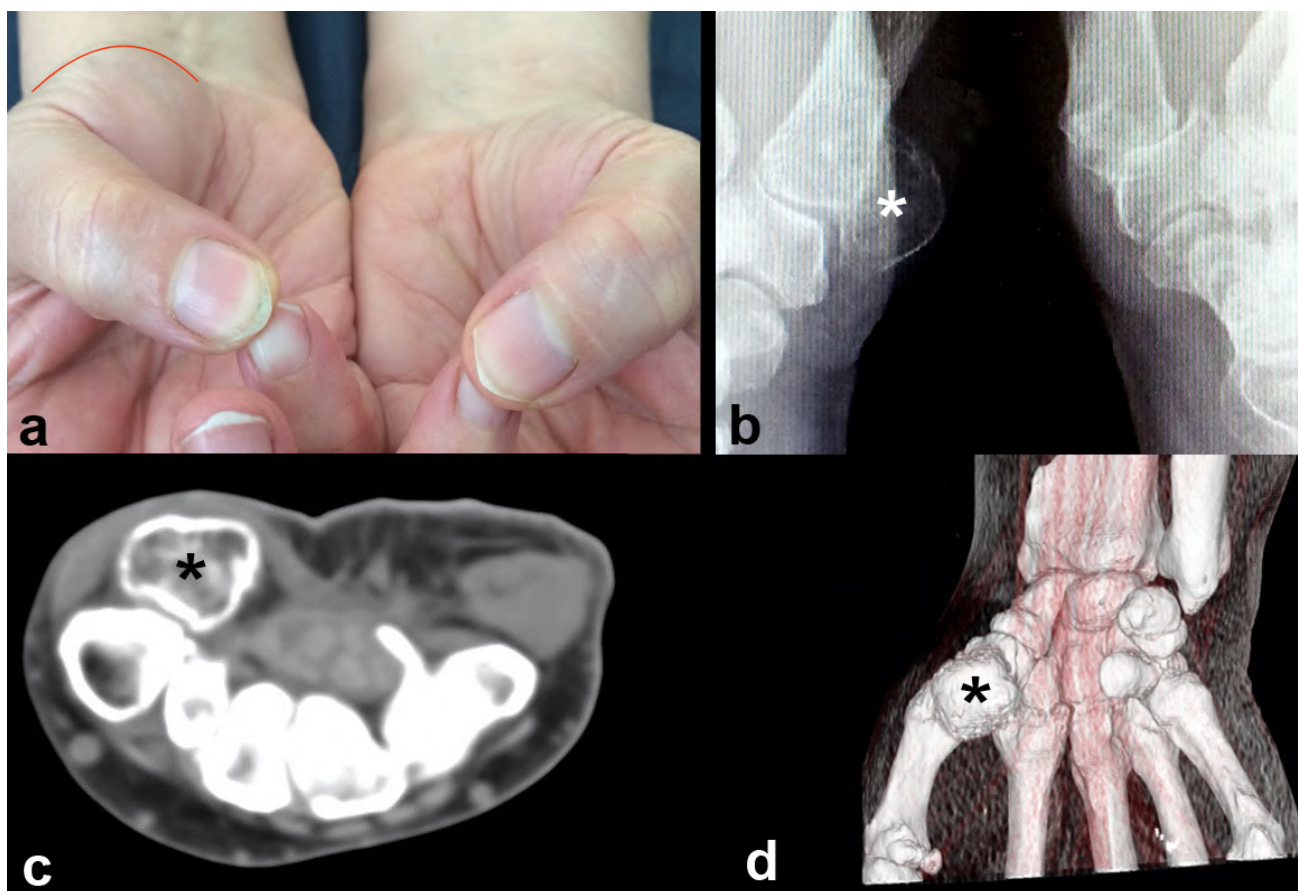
1A. Image of both hands of the patient. On the right thenar eminence an elevation can be observed, the red line outlining it, corresponding to the subjacent bone-like structure presence. 1B. Radiological image of the patient's right hand in oblique projection. The bone-like structure can be observed (white asterisk) anterior both to trapezium bone and the base of the first metacarpal. 1C. Axial CT-scan section image. The bone-like structure is an isolated supernumerary formation (black asterisk) fully independent of the surrounding adjacent bones. 1D. Three-dimensional CT-scan reconstruction showing the anterior surface of the supernumerary bone-like structure (black asterisk).
